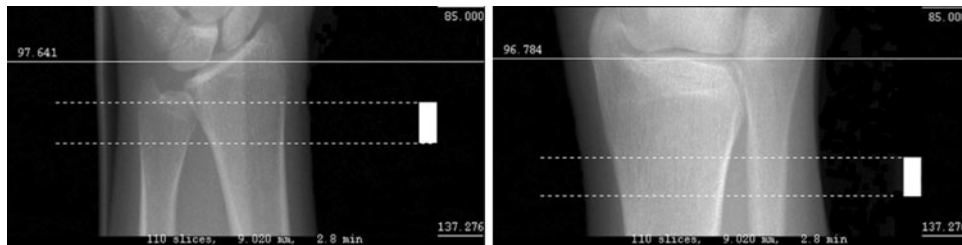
Positioning of the ROI at the tibia and the radius with HR-pQCT. Scout views demonstrating the reference line position (*solid line*) and the measurement site (between *dotted lines*). The first CT
